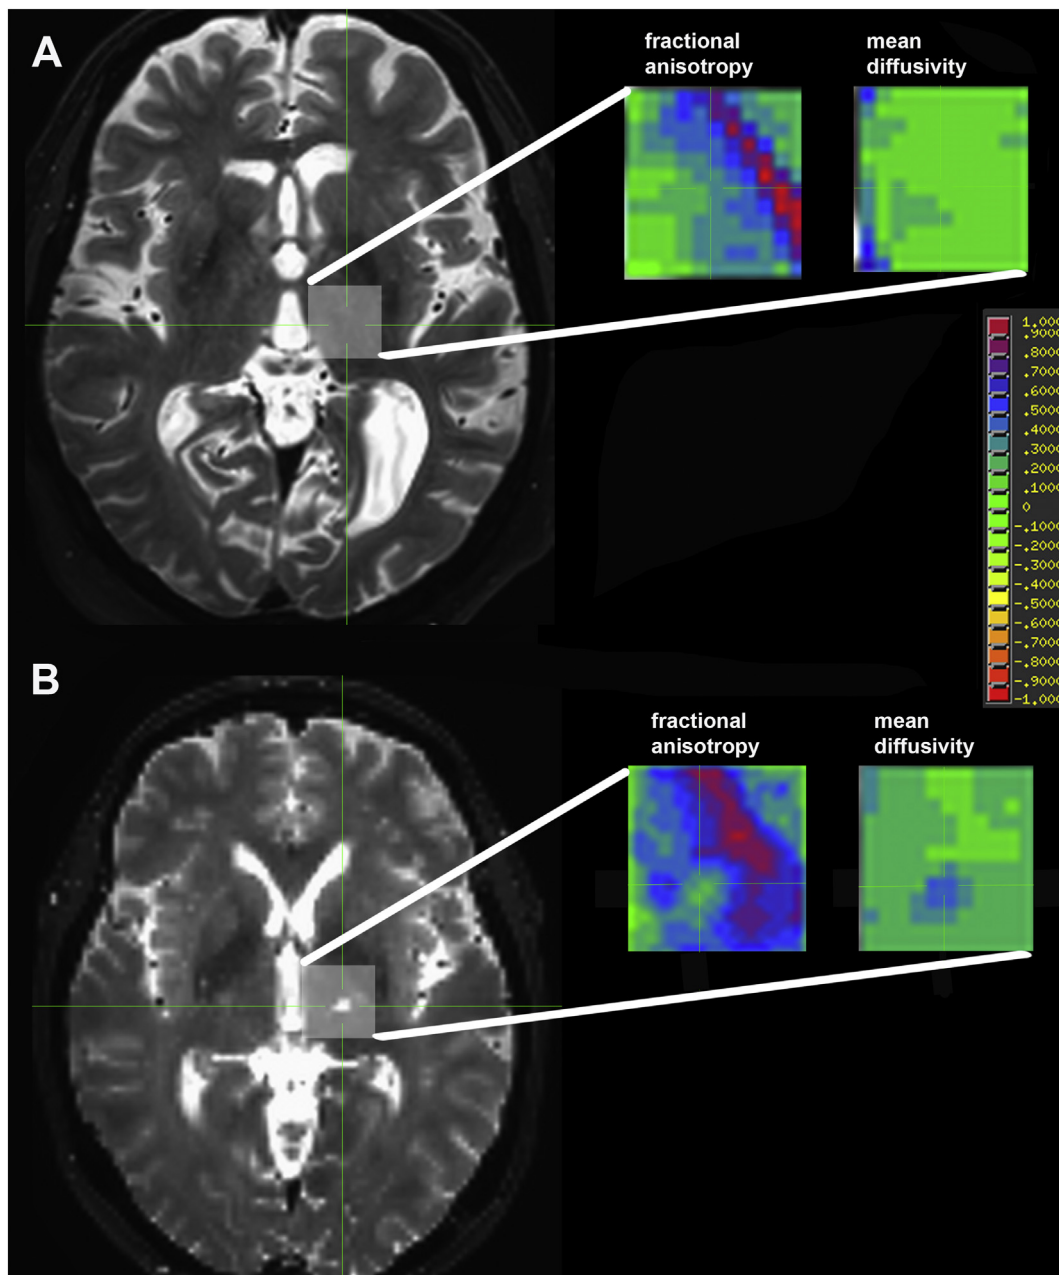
(A) Lesion boundaries become inconspicuous after FUS-T in contrast to radiofrequency thalamotomy (B). The structural T2-weighted images are compared between a patient with left radiofrequency thalamotomy (imaging obtained 18 years after surgery) and a patient (B) who had focused ultrasound thalamotomy (imaging obtained 1 year after surgery) for the treatment of essential tremor. In contrast to the radiofrequency lesion, both fractional anisotropy (FA) and mean diffusivity (MD) maps in the corresponding location fail to reveal the FUS-T lesion.
